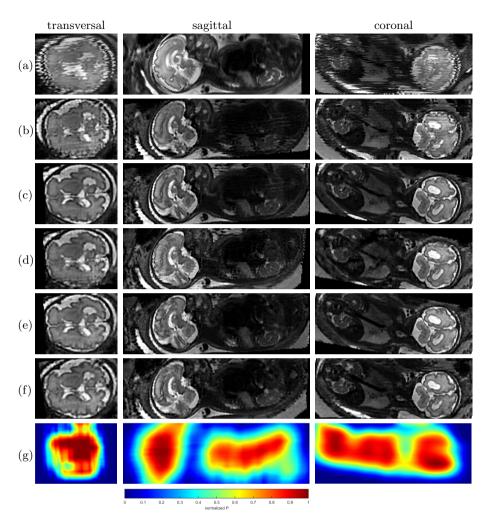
Visual comparison between the input data (a) and different configurations for full fetal body reconstruction of a motion corrupted 3T MRI dataset with gestational age of 33 weeks. The categorization into best and worst has been made by an expert. (b): reconstruction with full slices and [8]; (c): best: $s = 32 \times 16, \omega = 16$; (d): worst $s = 64 \times 64, \omega = 64$; (e): best: super-pixels k = 0.2 $\gamma = 16$, (f): worst: k = 0.05 super-pixels/slice $\gamma = 16$. (g) indicates which regions move as a rigid body as a function of P ($\sigma = 15$ with super-pixels $k = 0.2, \gamma = 16$) for subsequent automatic identification of rigid regions.
